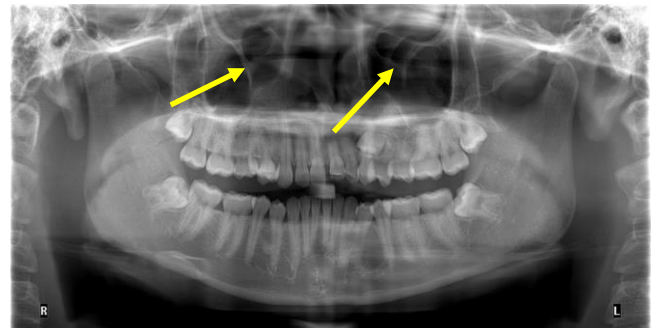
Panoramic radiograph showing irregular shape of Haller's cells on left side and round shape on right side (arrows).
